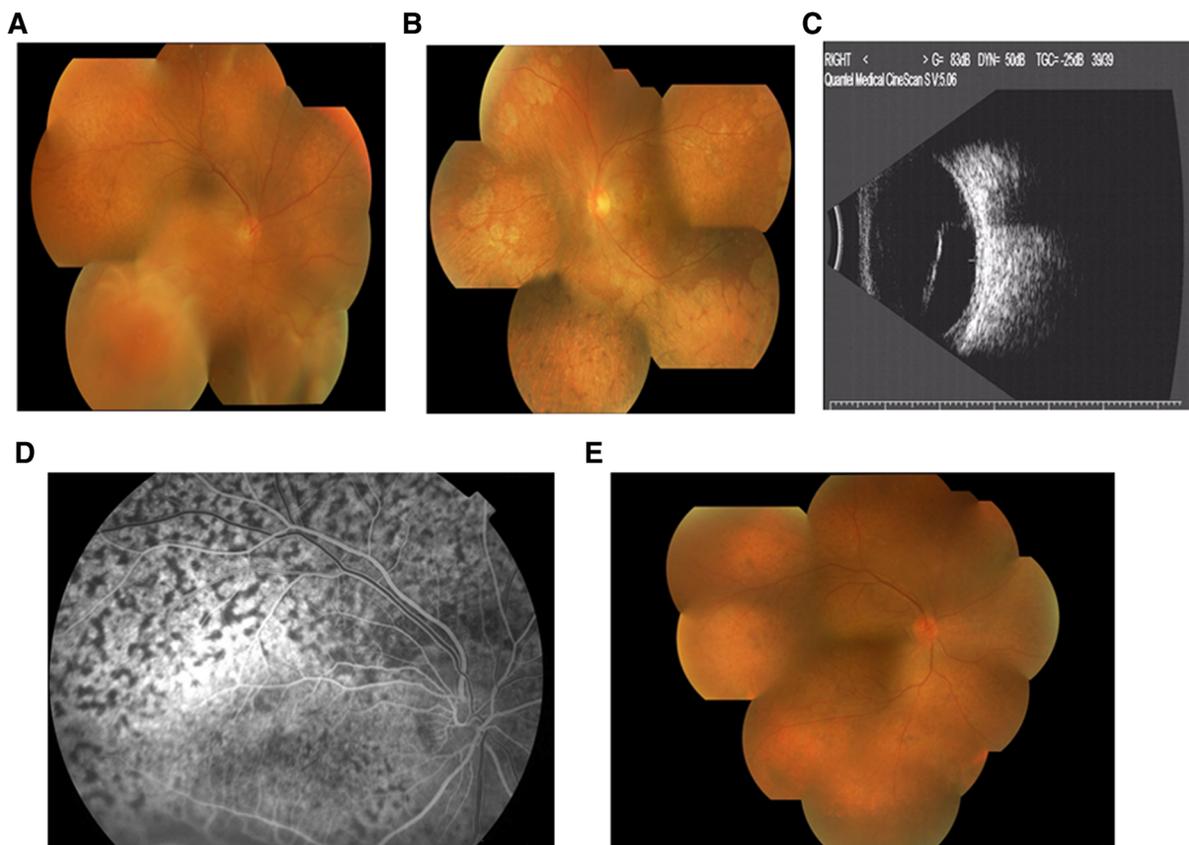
Fundus photographs of Case 2 on presentation: imaging revealed a inferior serous retinal detachment in the right eye (a) and typical ‘leopard-spot’ changes following resolution of a chronic serous retinal detachment in the left eye (b). Ultrasound
